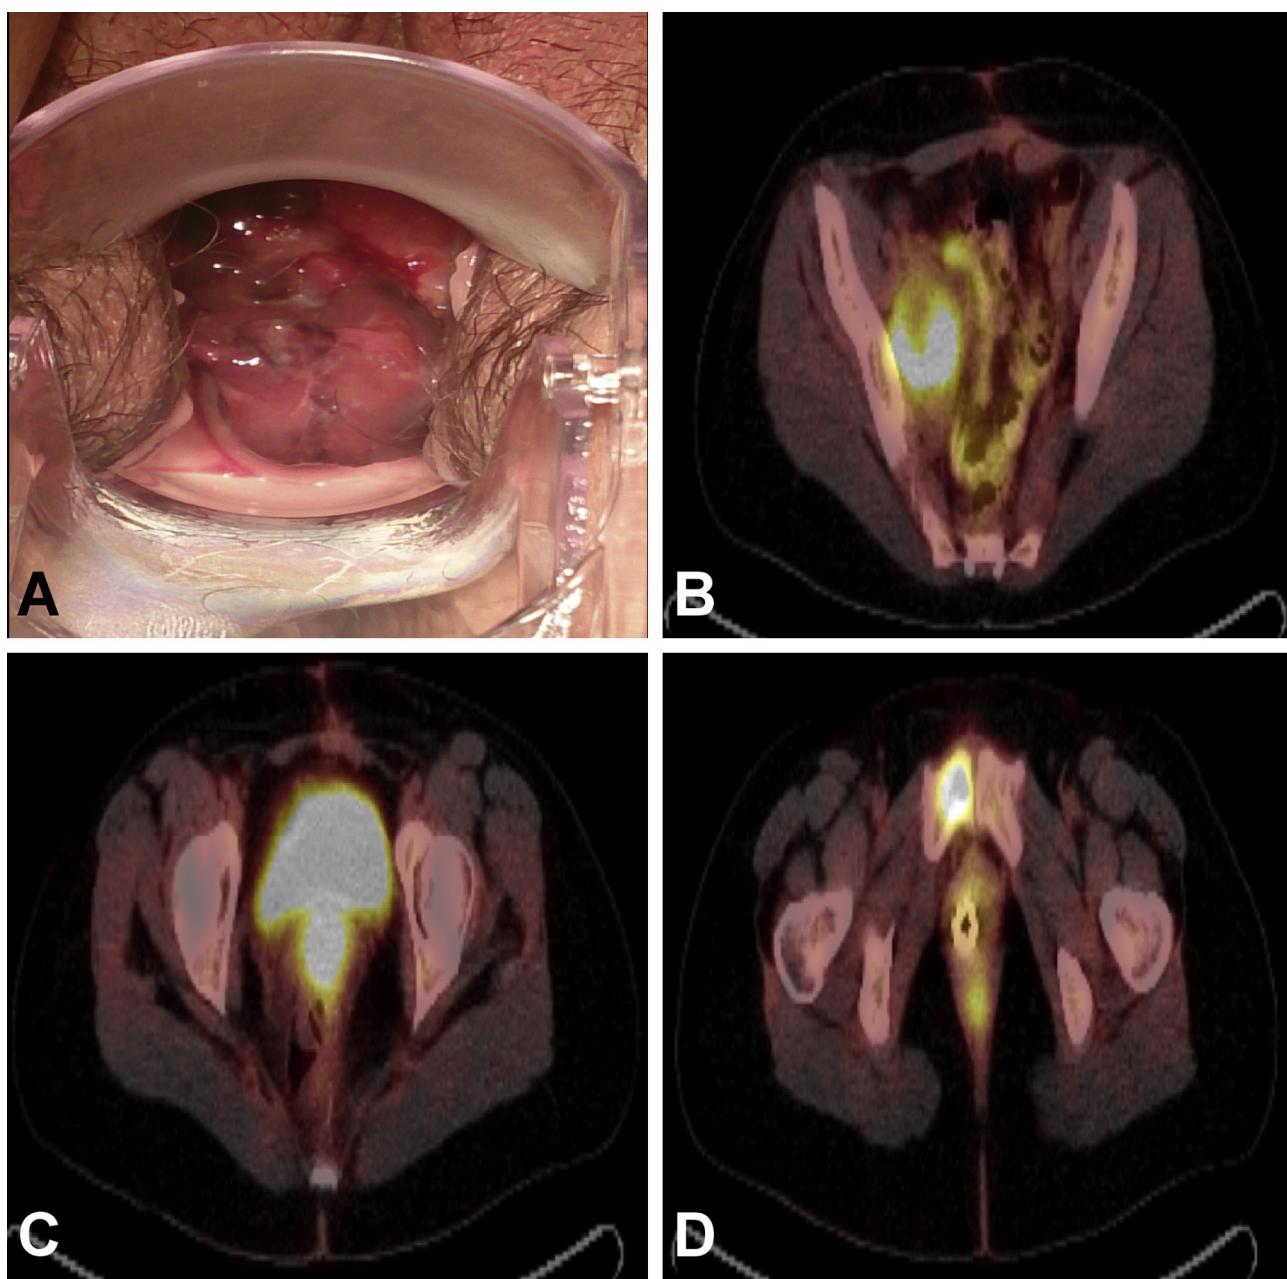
(A) Speculosity shows local tumor regrowth in the vaginal vault. (B) Positron emission tomography-computed tomography (PET-CT) shows intense capture of 18-fluorodeoxyglucose in the right iliac nodal conglomeration, which measured $44 \times 53 \times 57$ mm. (C) PET-CT shows hypermetabolic vaginal vault regrowth and a tumor measuring 76×39 mm. (D) PET-CT shows bony recurrence in the right pubic ramus.
